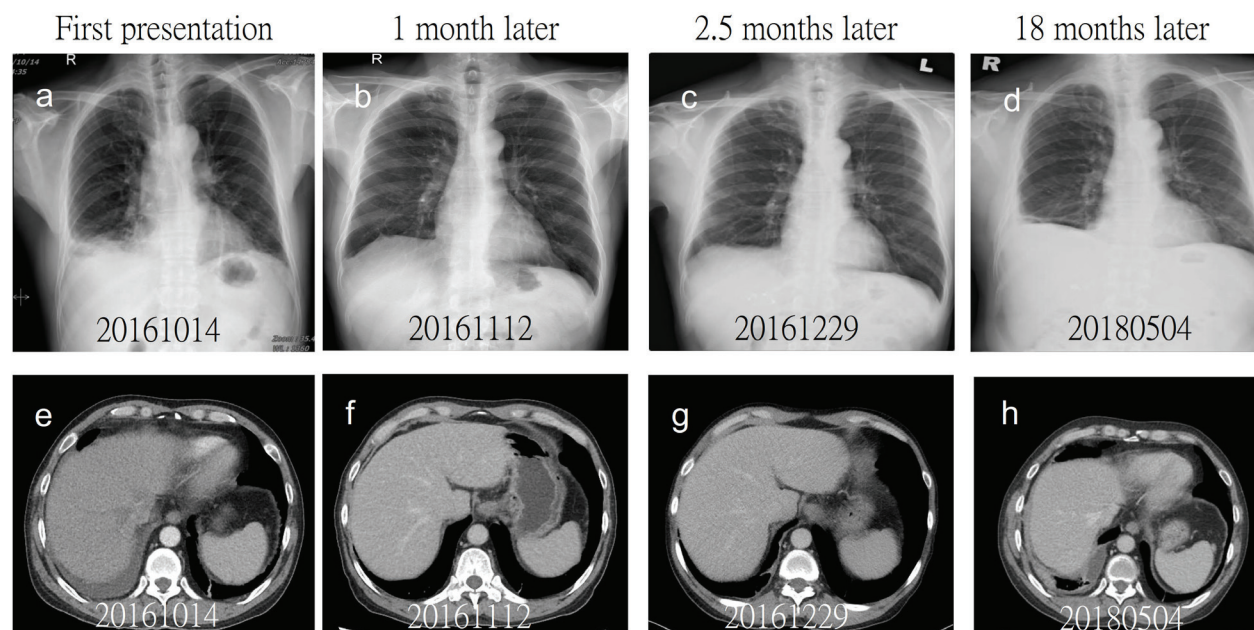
Chest X-ray (CXR) (a) demonstrated the right-side pleural effusion and computed tomography (CT) (e) revealed right-side pleural effusion at the first presentation on October 14, 2016. One month later, CXR (b) and CT (f) showed spontaneous remission of the right-side pleural effusion before laparoscopic cholecystectomy. Two and a half months post-operation, CXR (c) and CT (g) revealed only pleural thickening, and no pleural effusion. Eighteen months later, CXR (d) showed blunting of the right costophrenic angle and CT (h) revealed recurrence of the right-side pleural effusion, pleural thickening and multiple subpleural nodules.
